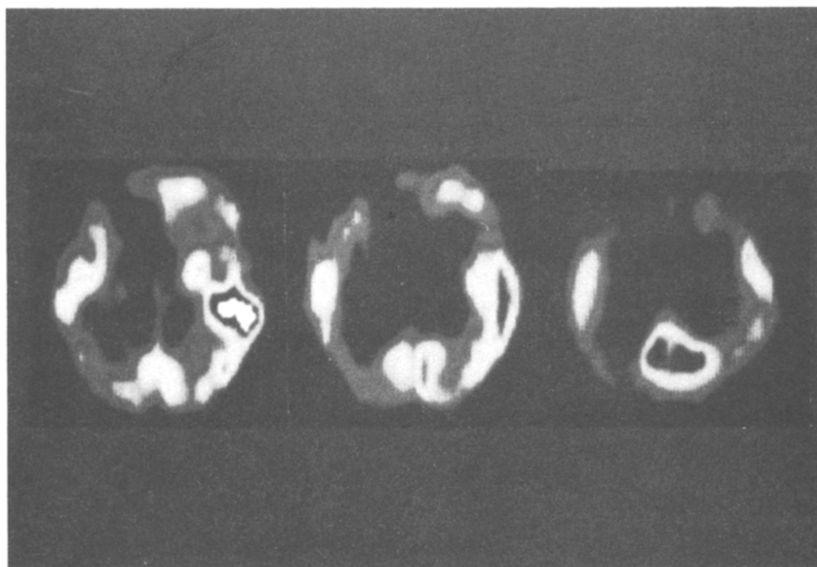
^{123}I -IMP SPECT at 1 month showed a decline in blood flow to the left hemisphere, particularly in the region extending from the left temporal lobe to parieto-occipital lobe.
